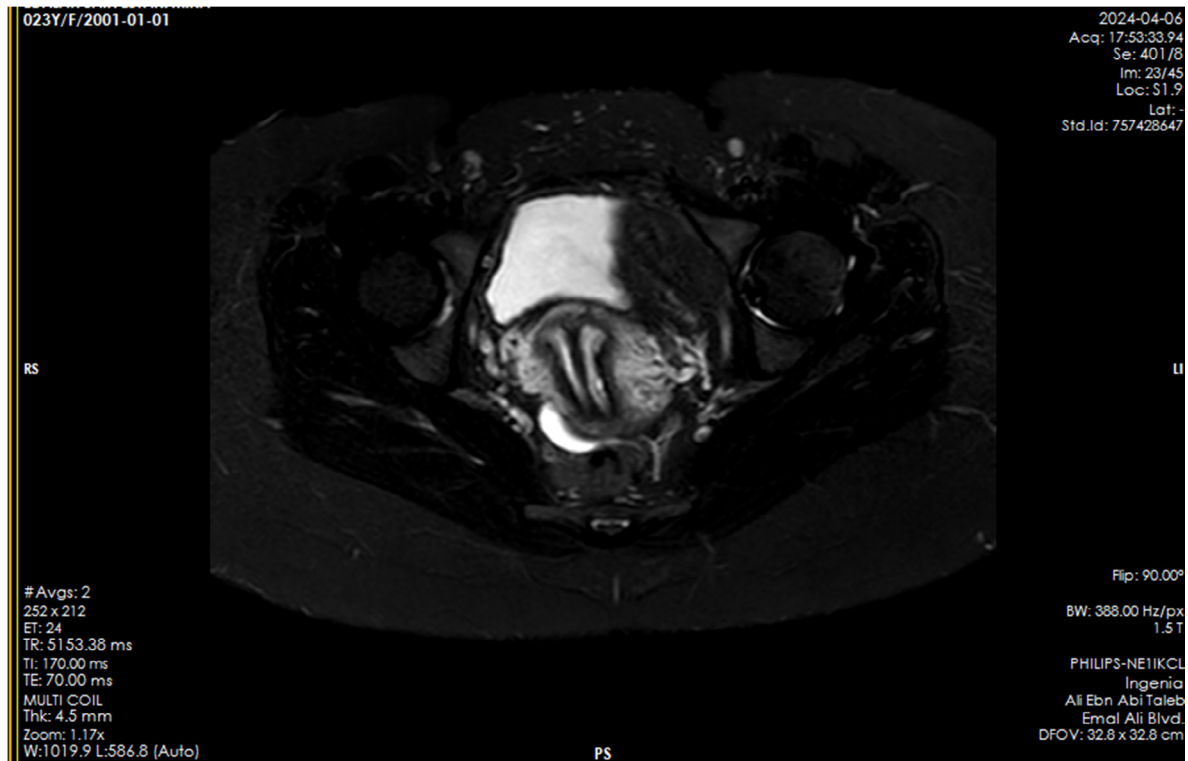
Axial T2-weighted STIR pelvic MRI reveals two separate uterine horns and two separated cervixes as didelphys uterus
